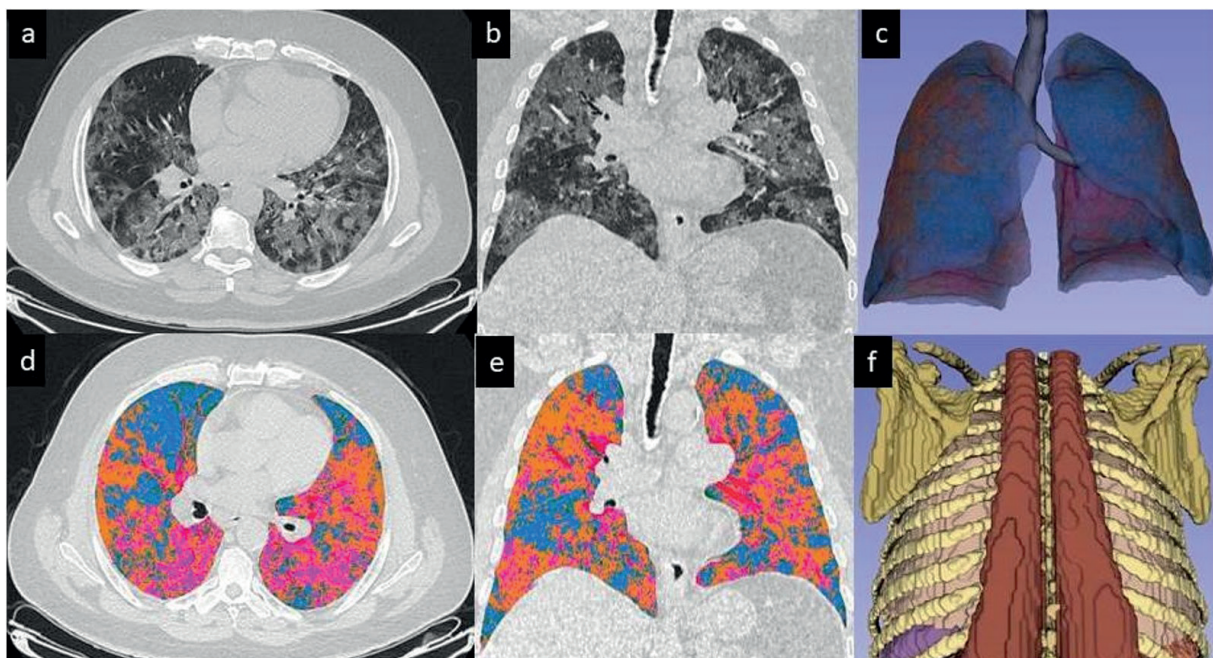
Images of a patient with COVID-19 pneumonia; axial (a), coronal (b) Chest CT images, three-dimensional volumetric (c), axial (d), coronal (e) lung, and erector spinae muscle (f) images obtained using 3D Slicer.
